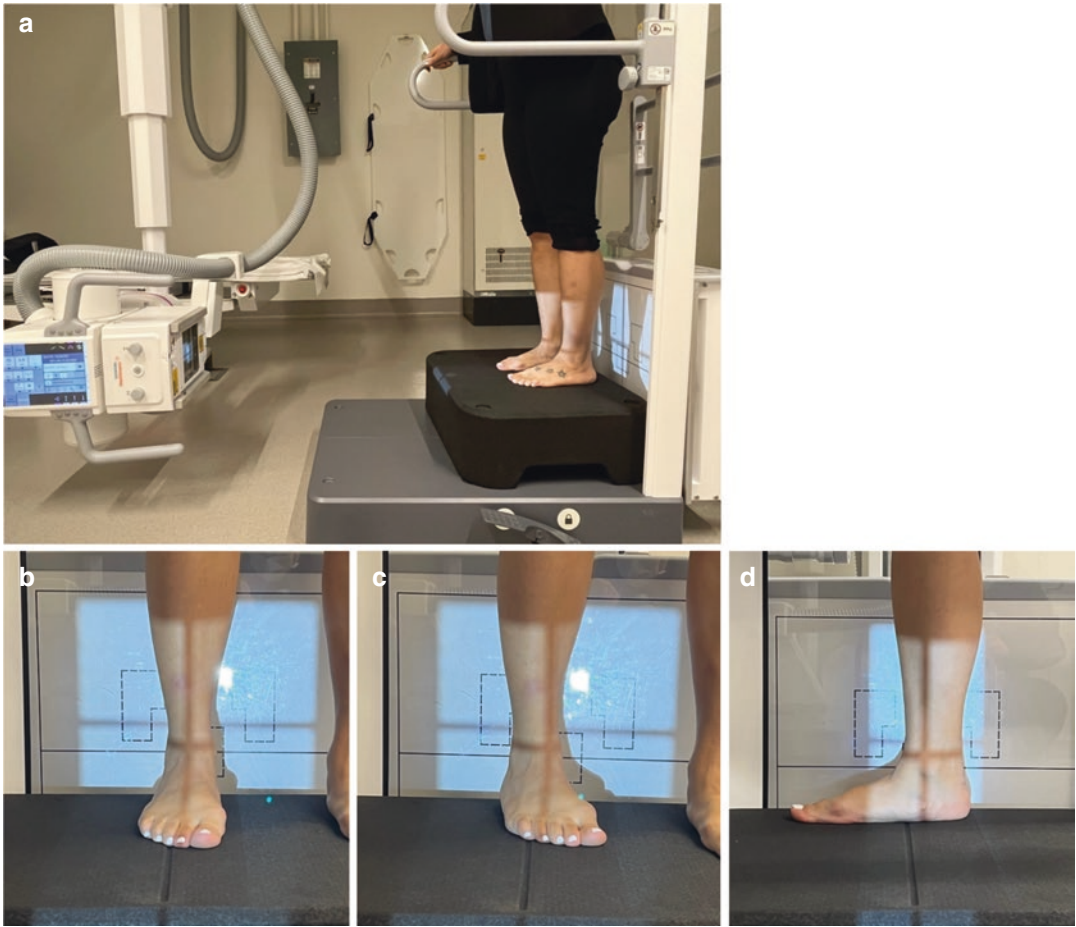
Techniques for the acquisition of standard weight-bearing radiographs of the ankle. (a) The patient stands on an elevated platform between the beam and the cassette. The beam is angled parallel to the floor. (b) Anteroposterior
